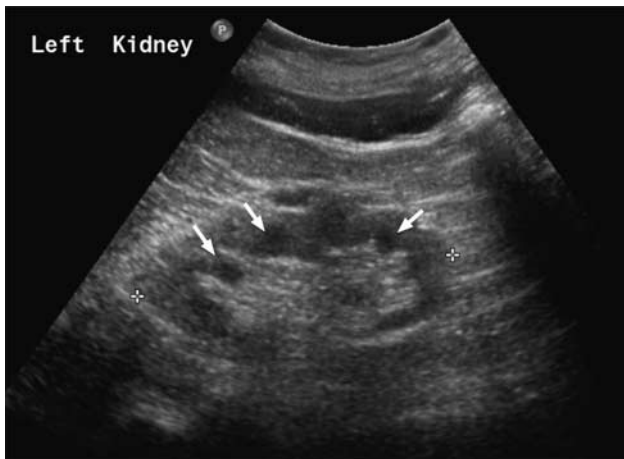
Ultrasound scan features of nephronophthisis. Renal ultrasound scan demonstrating corticomedullary cysts, some of which are arrowed.
